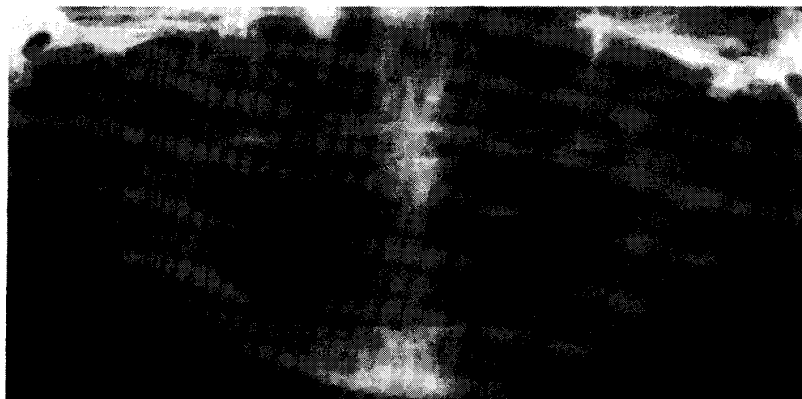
Subtraction Bone Image by Panoramic Radiography
